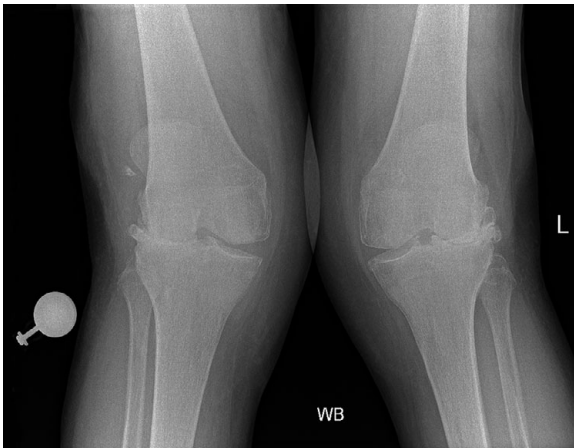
Anteroposterior (AP) radiograph both knees
